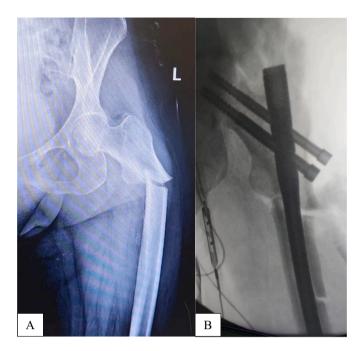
Initial radiograph of displaced subtrochanteric fracture (A) and post-operative radiograph with reconstruction nail in-situ. Note lateral corticotomy.
